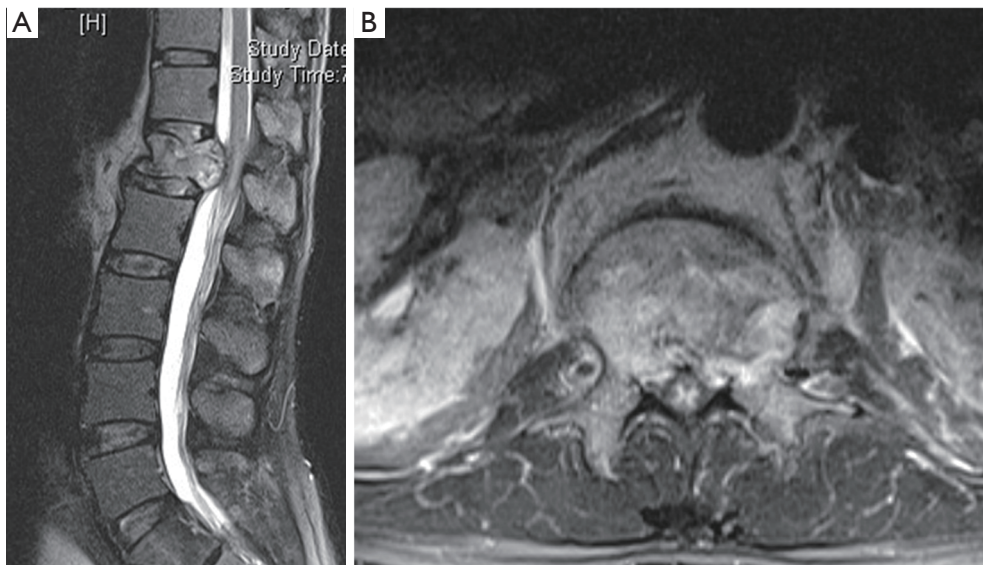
(A) Sagittal and (B) Axial MRI images of the thoracolumbar spine showing conus compression.
